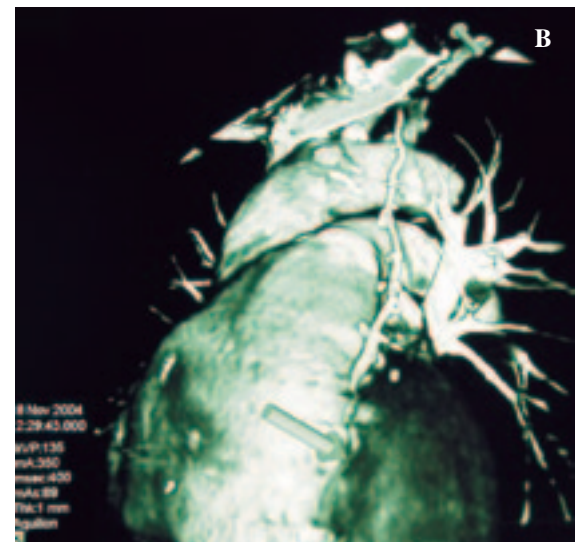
The 16-row spiral CT demonstrates (A) a patent carotid-subclavian polytetrafluoroethylene (PTFE) graft (white arrow), and (B) normal opacification of the left anterior descending branch through the left internal mammary artery (arrow).
